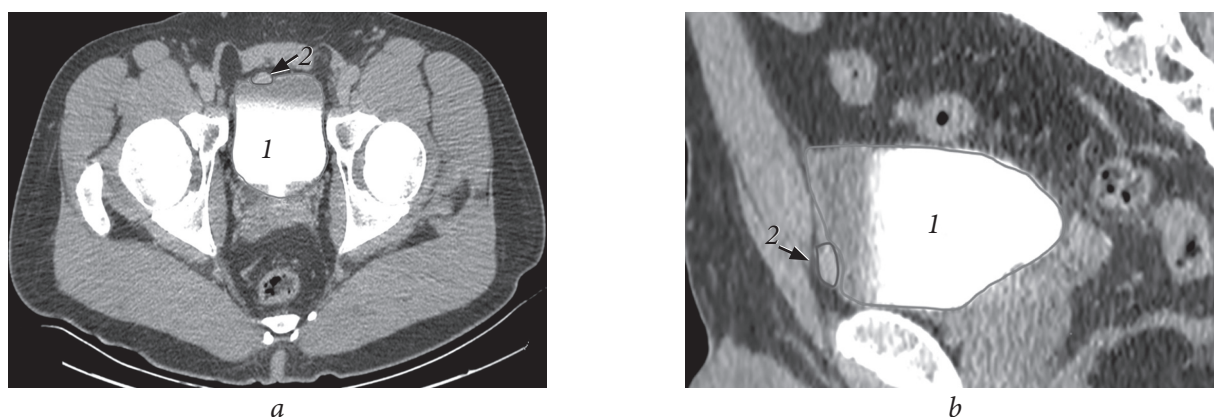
Computed tomography of the pelvis with contrast: *a* – axial projection; *b* – sagittal projection; 1 – bladder; 2 – neoplasm of the bladder
